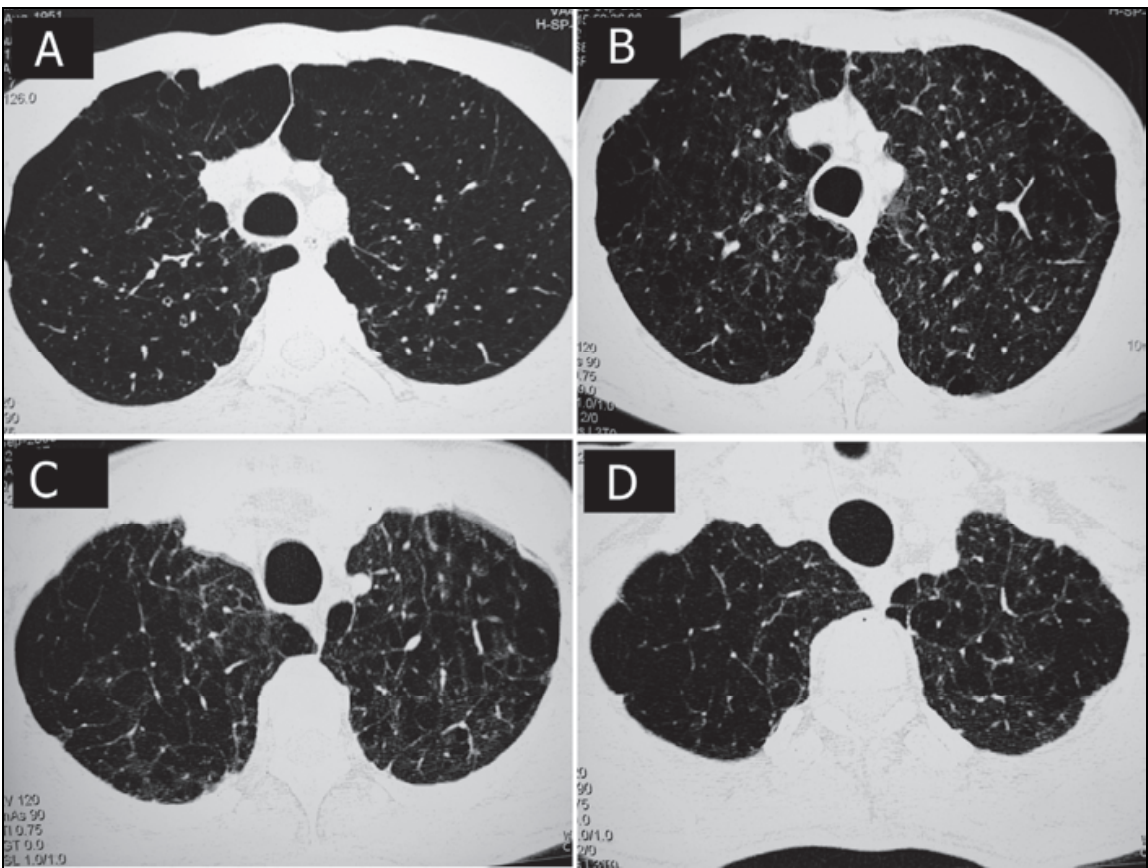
(A-D): HRCT scans showing small subpleural areas of hyperlucency – characteristic of paraseptal emphysema.
